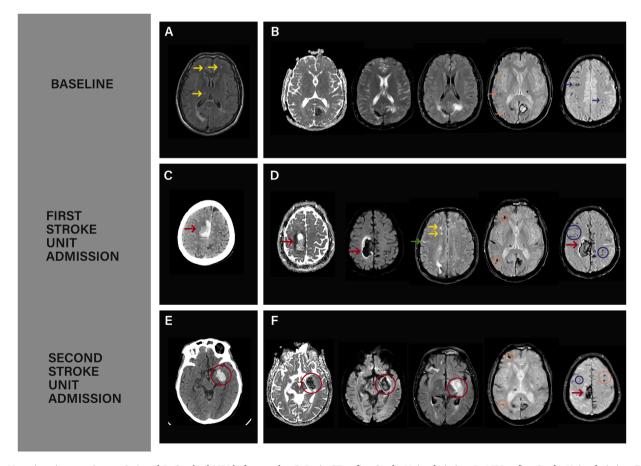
Neuroimaging tests in case 2. A and B: Cerebral MRI before stroke. C: Brain CT at first Stroke Unit admission. D: MRI at first Stroke Unit admission. E: Brain CT at second Stroke Unit admission. F: MRI at second Stroke Unit admission.
